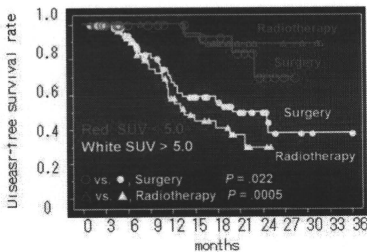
FDG-PET を用いた非小細胞癌における治療法別の検討。手術 (Surgery) 群 (n=93) と放射線治療 (Radiotherapy) 群 (n=69) 双方における腫瘍制御率を SUV 値 (cut-off, 5.0) を用いて比較。手術群、放射線治療群、いずれにおいても SUV が 5 以下の群で良好な腫瘍制御率を示す。(文献 1 より引用)
